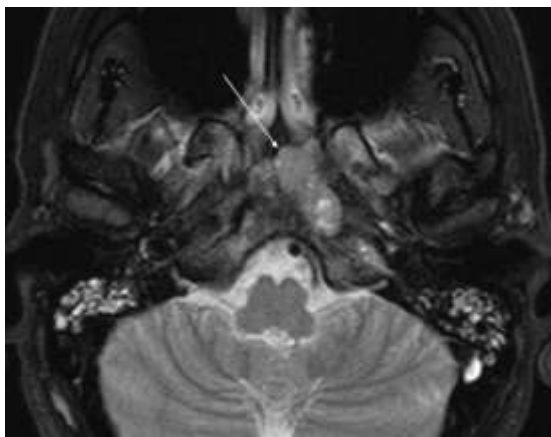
Nasopharyngeal squamous cell carcinoma; axial T2-weighted fast spin echo sequence with fat saturation showing a solid mass (arrow) extending through the pharyngotympanic tube (auditory tube) and infiltrating clivus bone structures with signs of petrous apex involvement (asterisk).
